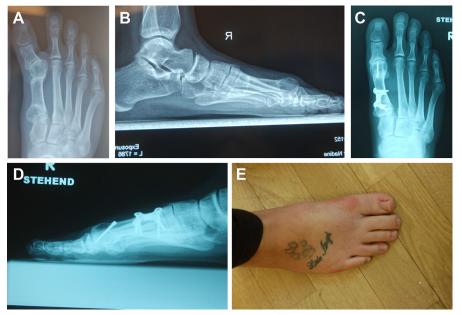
A 21-year-old female with dorsiflexion malunion and hallux varus following MIS double osteotomy is shown. (*A*) Preoperative AP radiograph. (*B*) Preoperative lateral radiograph. (*C*) AP radiograph shown at follow up after revision with Contra-Chevron osteotomy (performance of Chevron with medialization of the capital fragment) and plantarflexion osteotomy[SE1] [SE2] [HJT3] (*D*) Lateral radiograph at follow up. (*E*) Clinical picture of the same patient at follow up.
